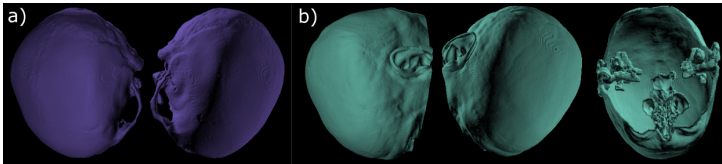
a) Segmented skull from a CT head scan. b) Segmented skin.
